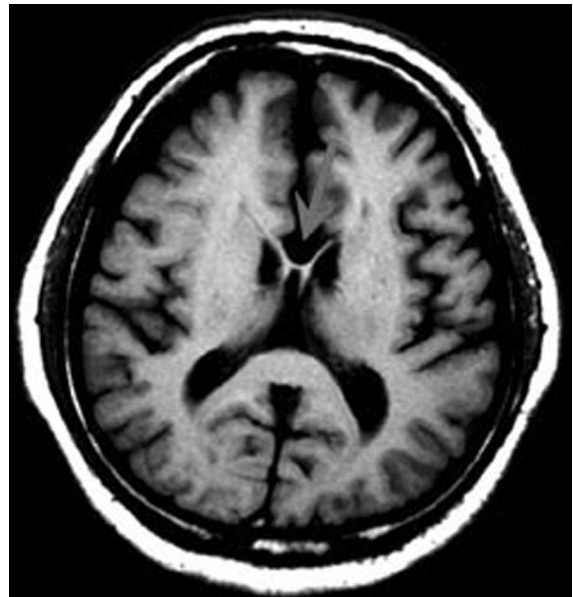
Callosal agenesis. (a) Coronal MRI of complete agenesis. (b) Horizontal MRI of partial agenesis; the splenium is spared. The arrow depicts the intact optic chiasm (the point where about half the axons of the optic nerve from each eye cross to the other side).
